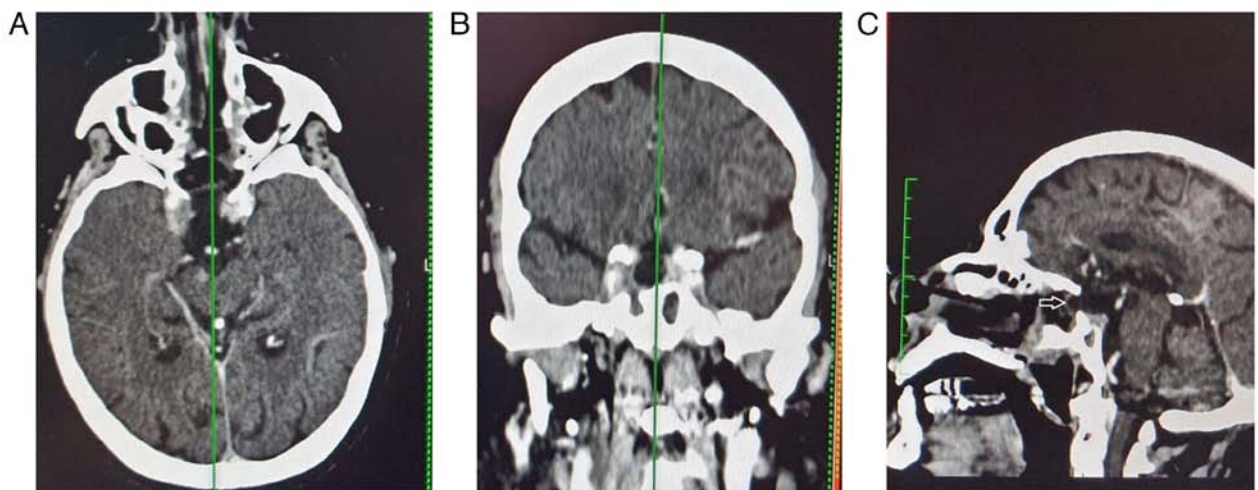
(A-C) Contrast enhanced computed tomography scan of patient 1 following the endonasal endoscopic gross total removal of the macroadenoma. Note the duroplasty materials (arrow).
